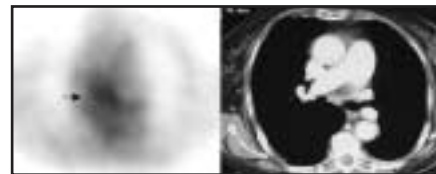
FDG-PET imaging performed on 81-year-old woman with history of renal cell carcinoma, persistent fevers, and no localizing signs demonstrates a hypermetabolic focus in mediastinum (arrow), corresponding to CT-identified lymphadenopathy. Biopsy confirmed mediastinal lymph node involvement by metastatic renal cell carcinoma.
